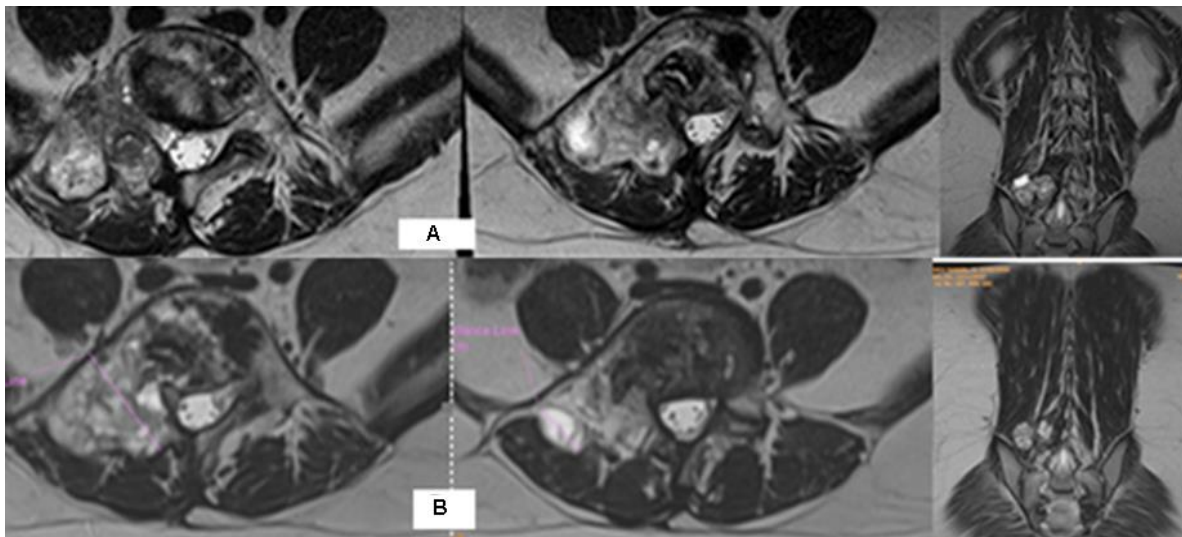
A/ MRI after 6 months of IMRT - without significant reverse dynamics of the aneurysmal bone cyst; B/ MRI after 9 months of IMRT - The structure of the formation is heterogeneous with confluent hyperintense areas in T2 and STIR, hypointense in T1, as well as the presence of reticular osteosclerotic areas.
